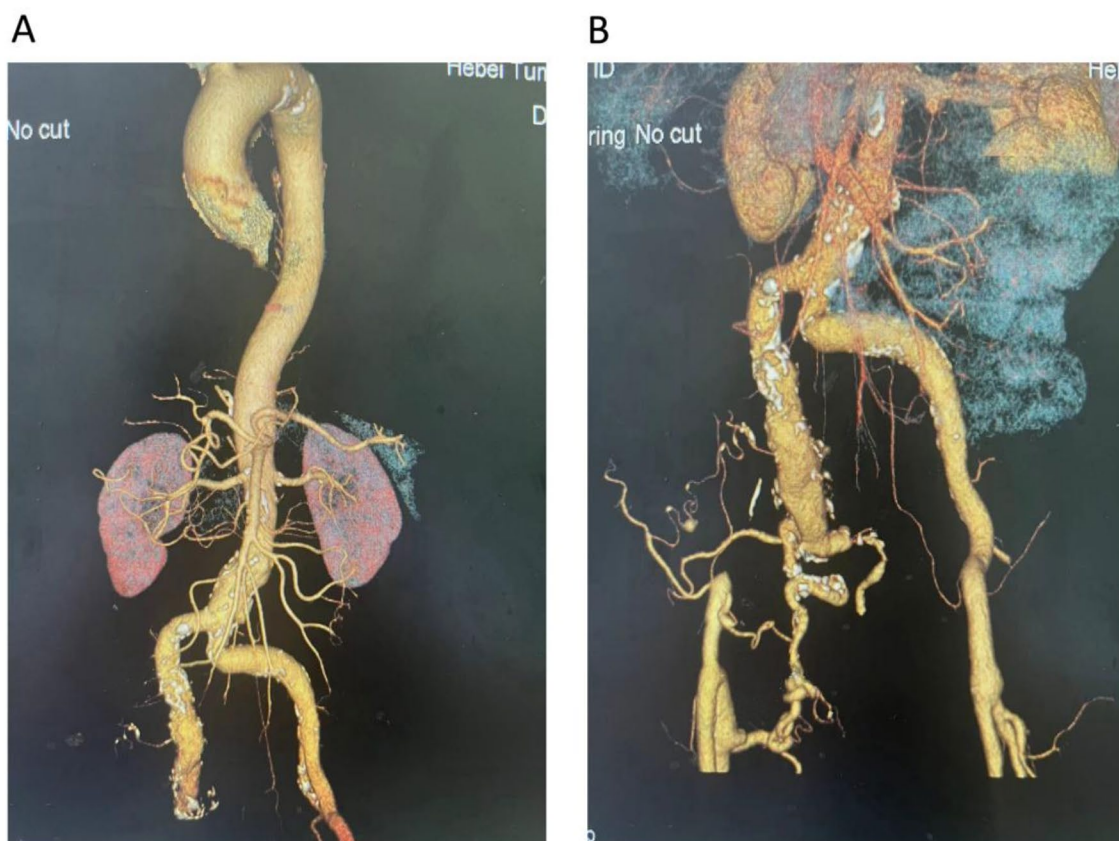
A. Preoperative CTA three-dimensional reconstruction of blood vessels revealed AAA and right internal iliac aneurysm. B. Preoperative CTA three-dimensional reconstruction of blood vessels showed that the diameter of deep femoral artery increased, and the deep femoral artery communicated with IIA
